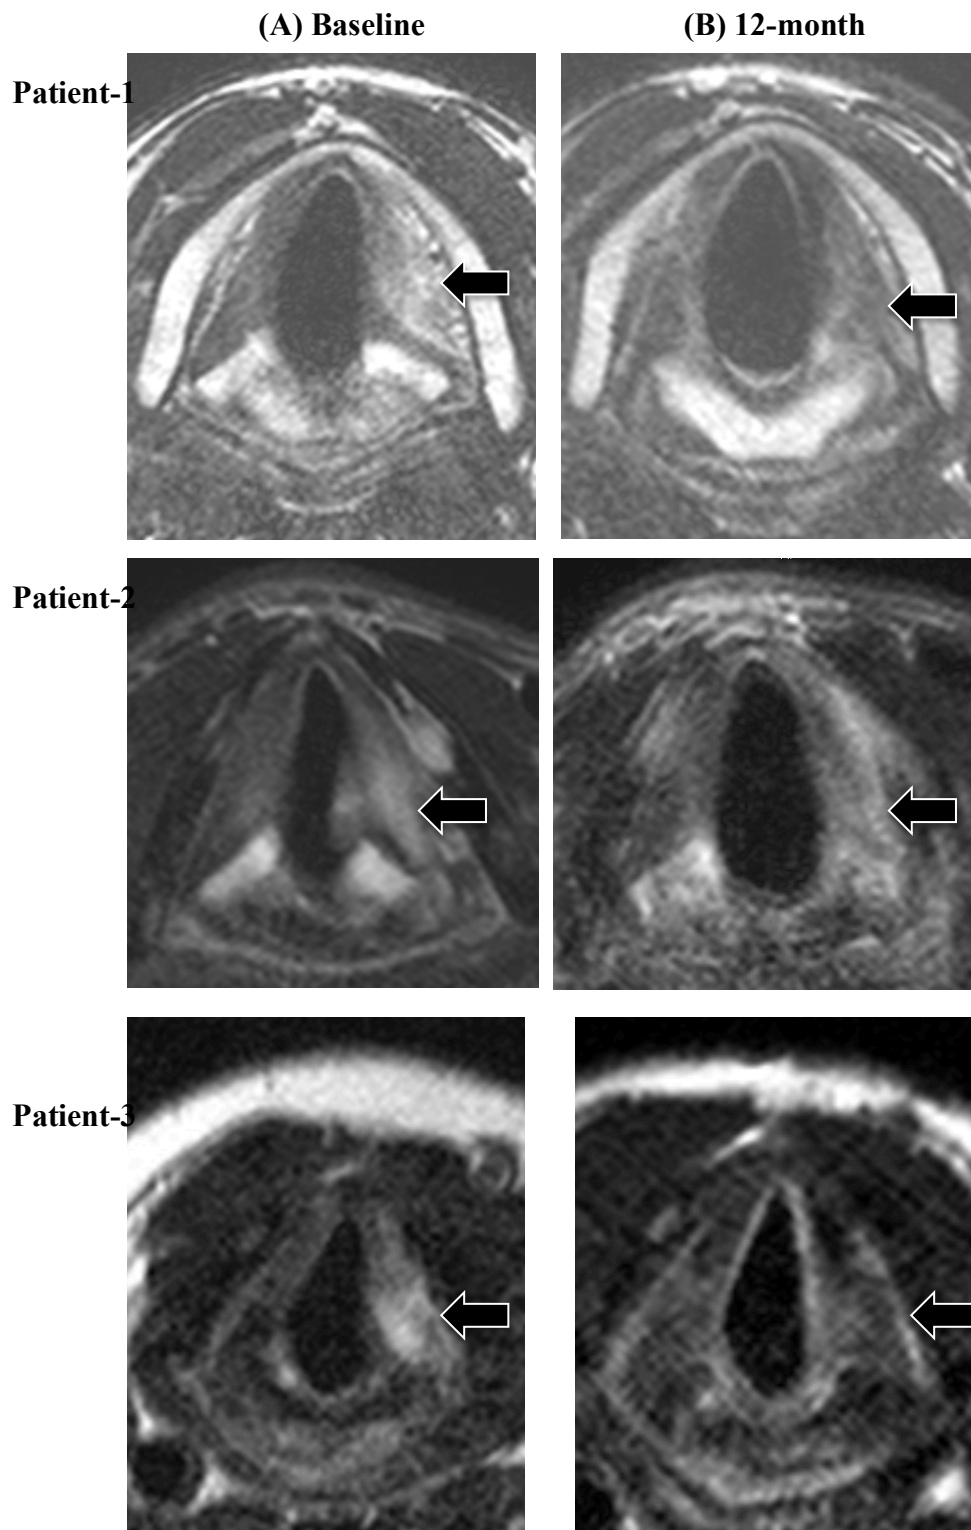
T2-weighted imaging of vocal folds images of patient-1, -2 and -3. Images on column (A) are taken at baseline and column (B) at 12-month. At baseline, the paralysed thyroarytenoid muscles (white arrow) had higher signal intensity than the opposite normal. The signal intensity normalised at 12-month except in patient-2
